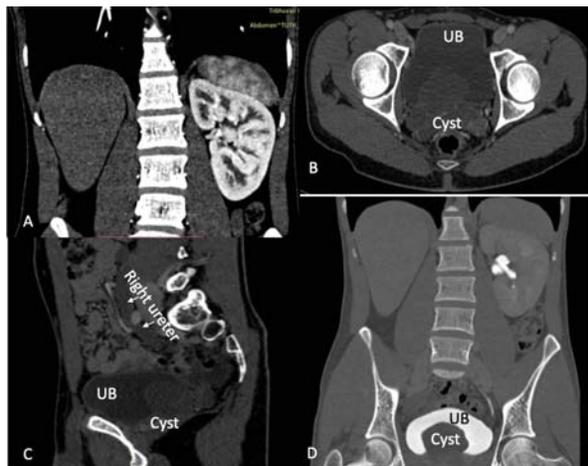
CT Urography images –
